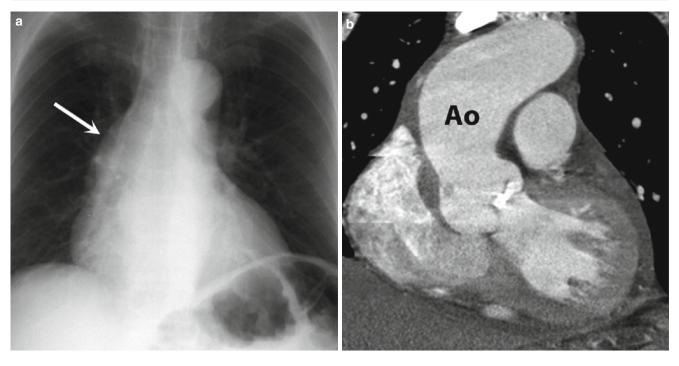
Aortic stenosis. (a) PA radiograph shows ascending aortic enlargement (*arrow*). (b) Coronal CT confirms aortic enlargement (*Ao*). Note aortic valvular calcification. This patient had severe aortic stenosis documented by echocardiography
